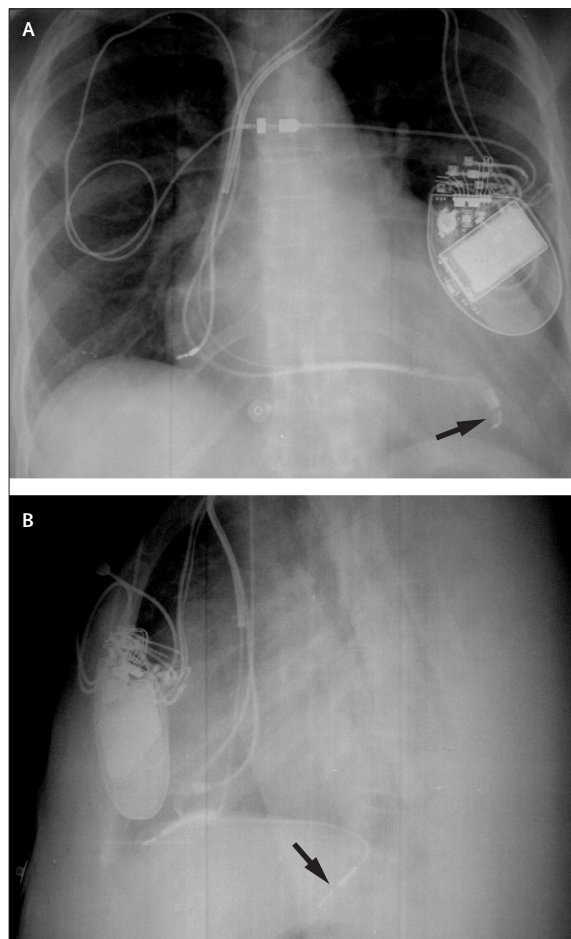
Chest radiographs showing lead placements
